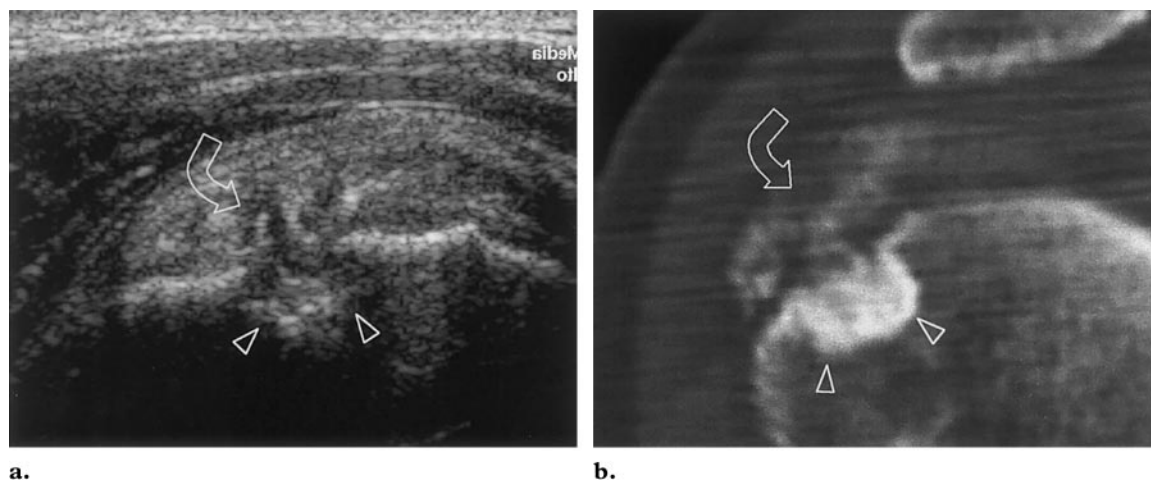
Intraosseous loculation of calcifying tendinitis in a 54-year-old man with boring shoulder pain. (a) Longitudinal 12–5-MHz US image of the supraspinatus tendon demonstrates calcific slurry (arrow) within the tendon. The calcific material extends into a deep cavity within the greater tuberosity (arrowheads). (b) Corresponding CT scan demonstrates the calcifications (arrow) and the cavity within the greater tuberosity (arrowheads).
